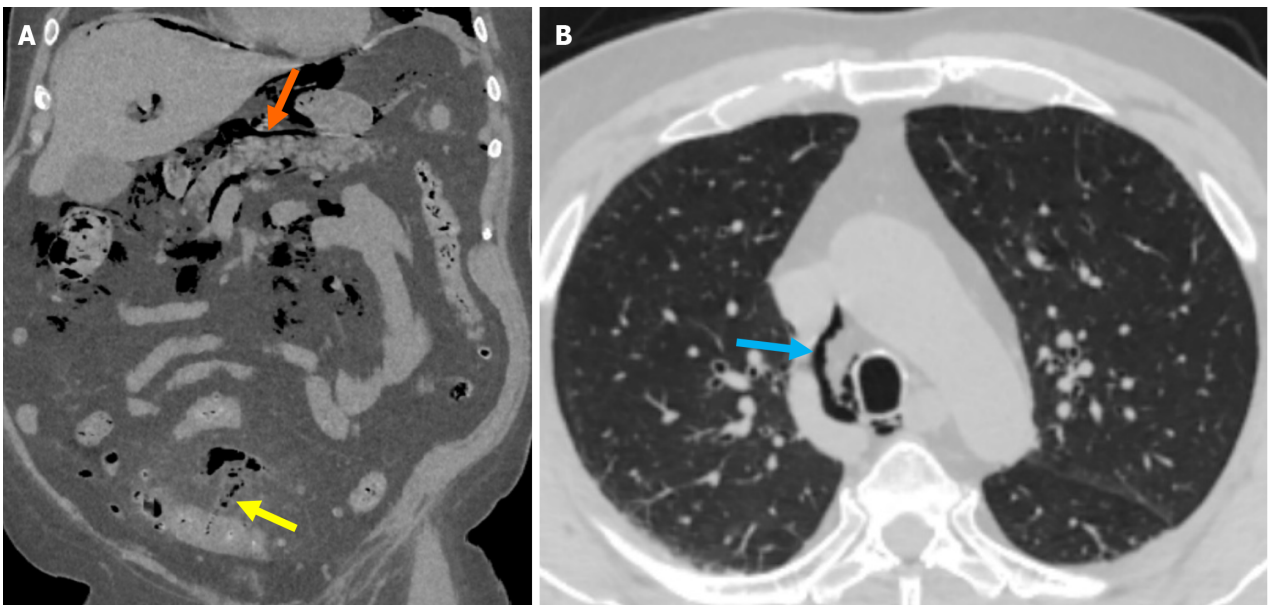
Free air extending to the mediastinum due to sigmoid colon diverticulitis perforation. A: Non-contrast coronal reformatted computed tomography (CT) image at the abdominal level demonstrated the presence of air in the mesentery of the sigmoid colon (yellow arrow), consistent with perforation. The air was seen surrounding the portal structures in the hepatic hilum and extending retroperitoneally (orange arrow); B: Lung window axial CT image at the thoracic level showed that the air column extended to the mediastinum (blue arrow).
